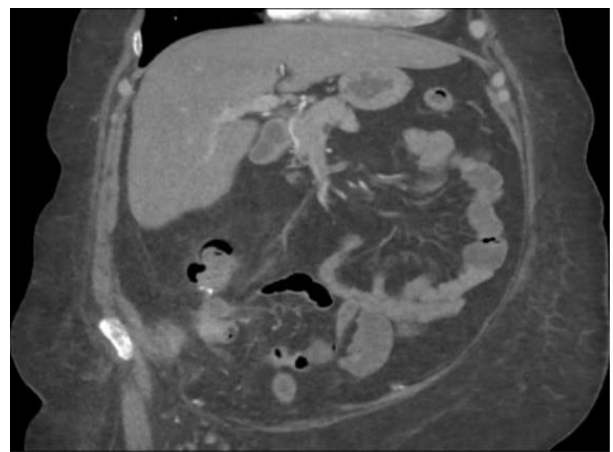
Follow up CT angio of regression of haematoma.
